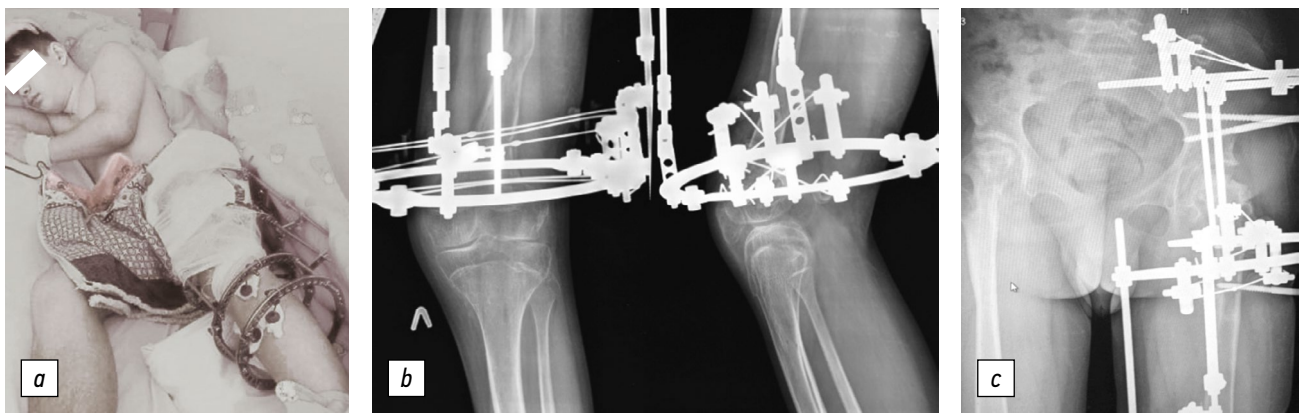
Photograph of the patient (a) and left knee (b) and hip (c) joint radiograph at the stage of left femur lengthening
